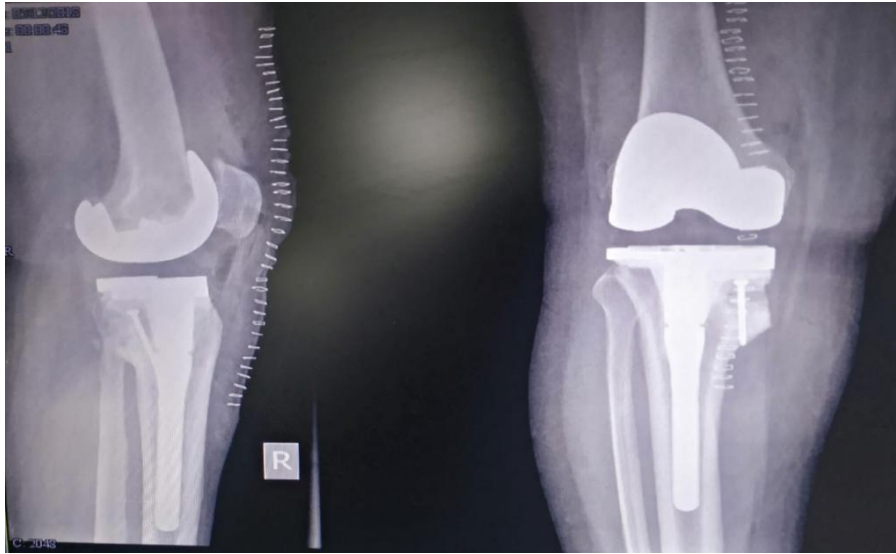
Post-operative Radiograph of Operated Knee with Deformity
